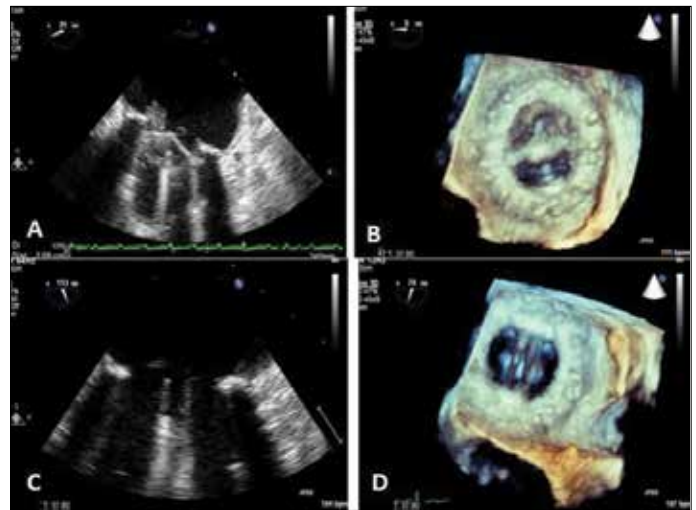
Obstructive thrombosis impairing occluder movement shown by two dimensional transesophageal echocardiography (A) and real time transesophageal echocardiography (B). After thrombolysis, 2D-TEE (C) and RT-3D TEE (D) demonstrated normally functioning mitral valve, without evidence of thrombus
